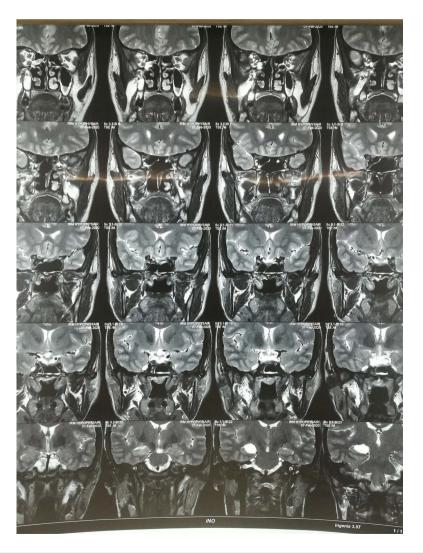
Post operative MR images, performed 1 year after surgery revealed complete evacuation of the abscess, with no obvious intrasellae pathological condition.
